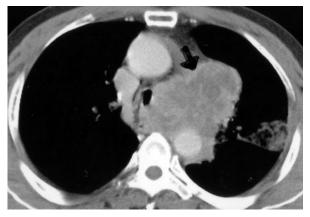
Chest computed tomography imaging showing a left upper lung mass with mediastinal lymphadenopathy causing mild compression of the trachea (arrow).
